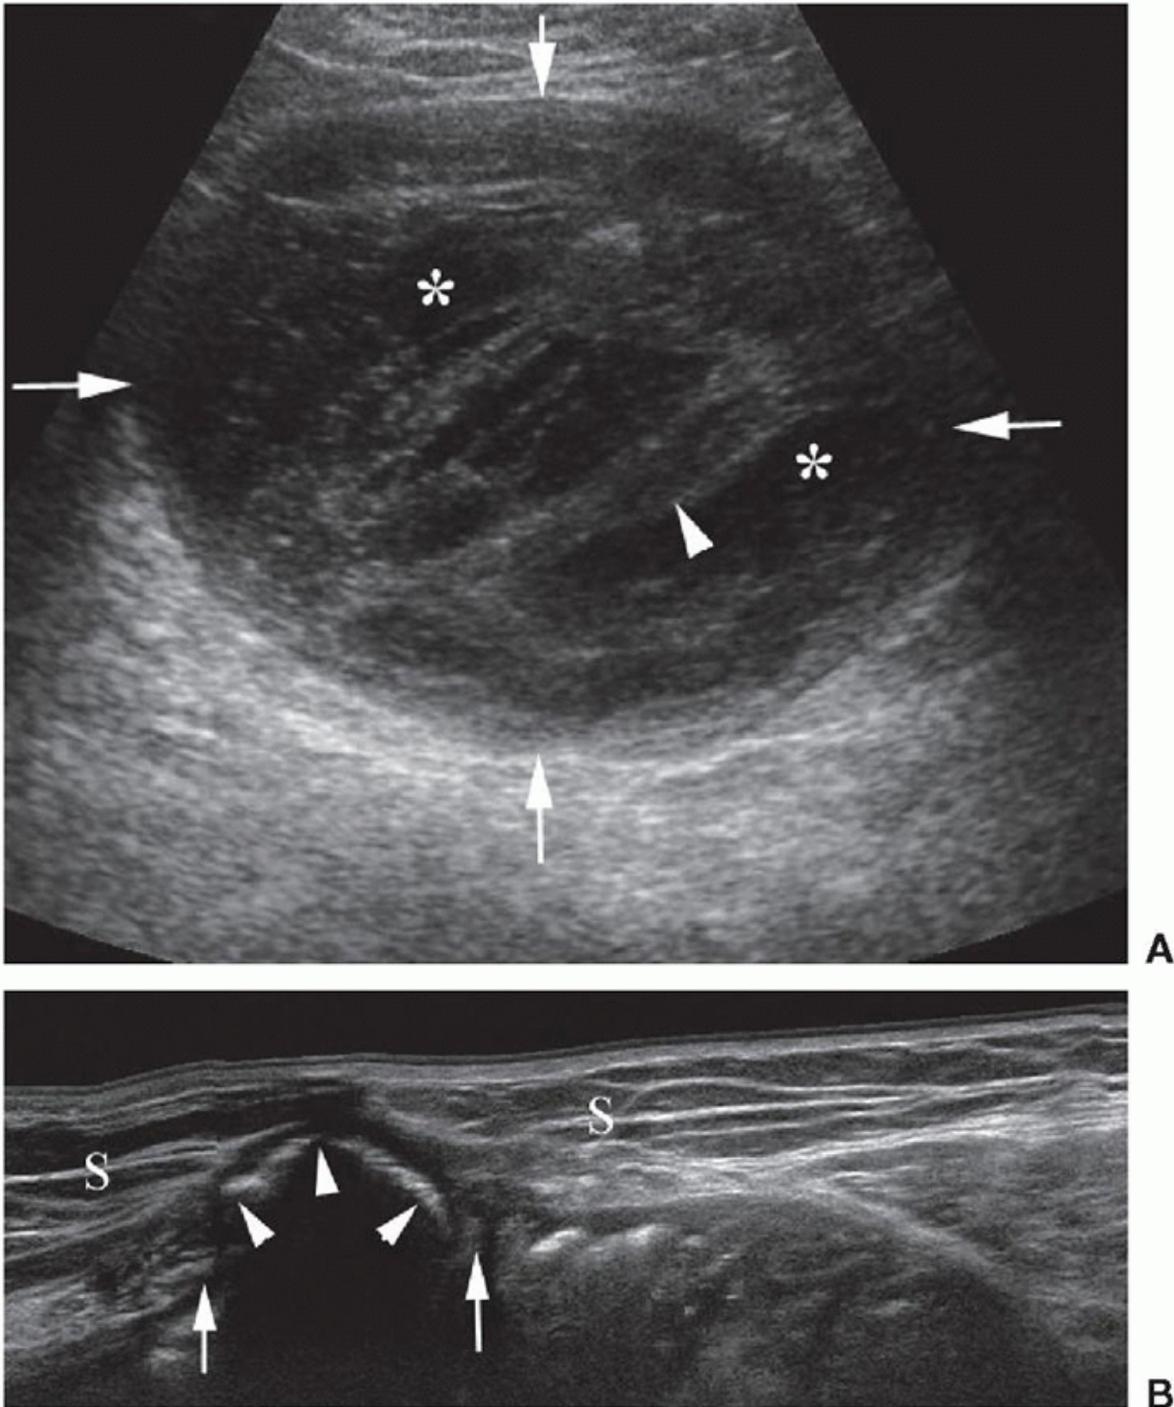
Postoperative changes. A: Transverse sonogram of the inguinal canal post direct hernia repair surgery shows hematoma (arrows) expanding the inguinal canal with echogenic stranding (arrowhead) and liquefied areas (asterisk). B: Longitudinal sonogram of a recurrent incisional hernia containing echogenic mesh (arrowheads) extending through a fascial defect (arrows) into the subcutaneous fat (S).
